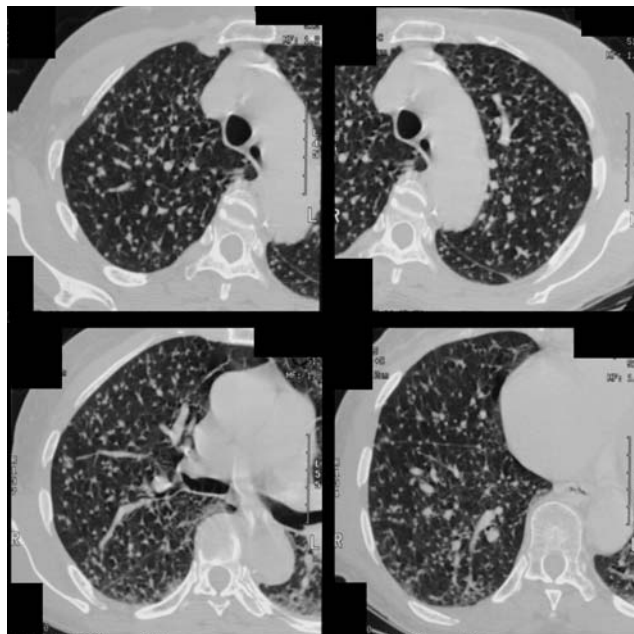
High Resolution CT scan of chest.
